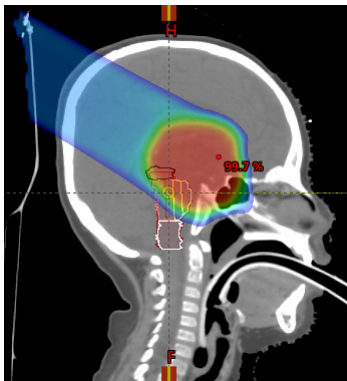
CT picture of vertical view of the head of a brain tumour patient with isodose curves showing the dose distribution of the treatment. Image is created with Eclipse TPS.
